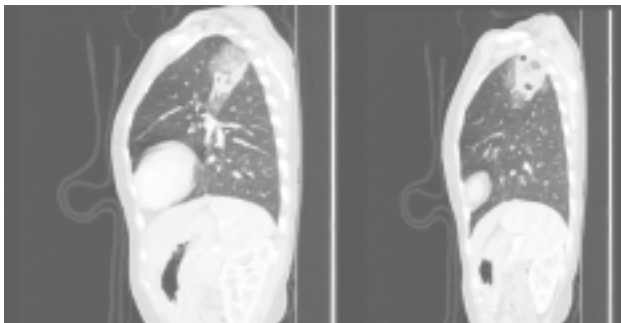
High resolution CT of chest.
